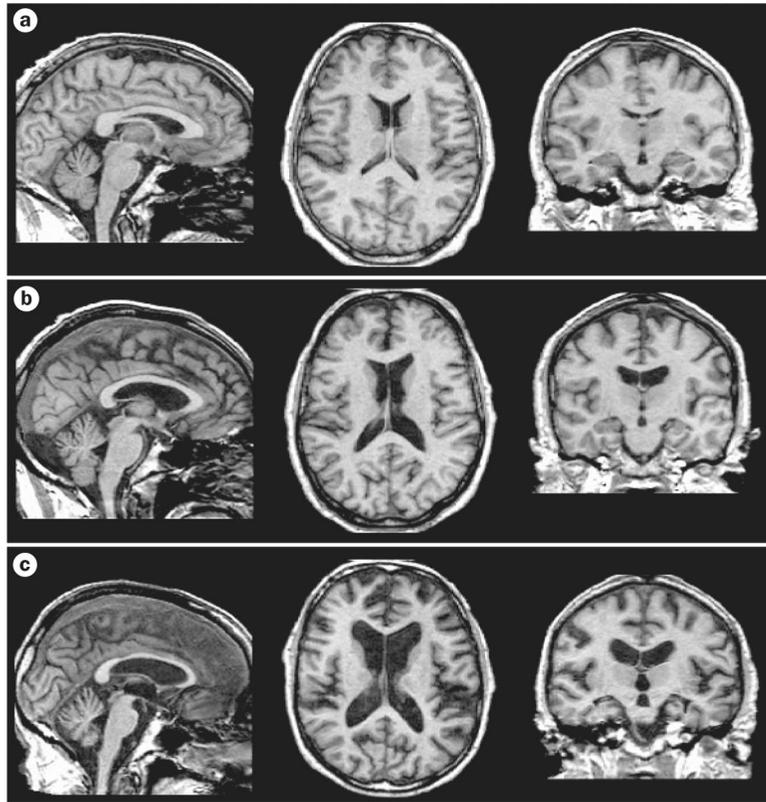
Graded brain-volume deficits in alcoholism and its sequelae. T1-weighted MRI scans from a | a 63-year-old healthy control male, b | a 59-year-old man with alcoholism, and c | a 63-year-old man with WKS. Graded enlargement of the ventricles (indicating shrinkage of the surrounding tissue) can be observed from the healthy control to the individual with WKS. Sagittal (left column), axial (middle column) and coronal (right column) brain images are shown. Abbreviation: WKS, Wernicke–Korsakoff syndrome. Figure courtesy of A. Pfefferbaum, SRI International, CA, USA.
